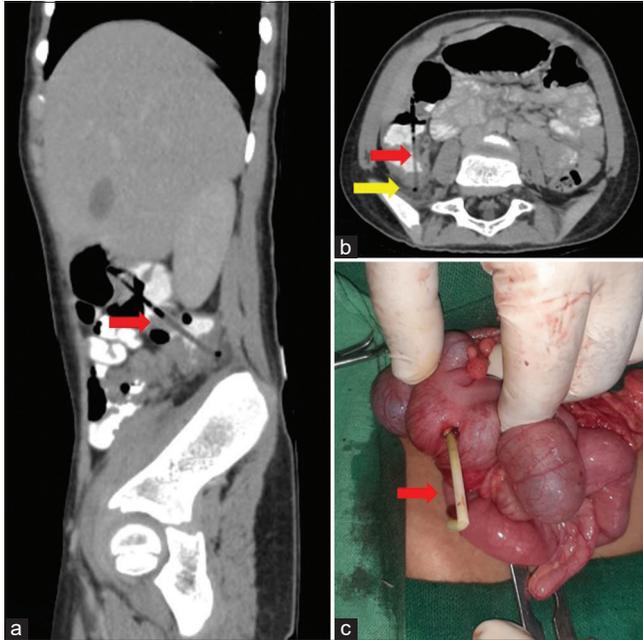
Sagittal and axial reformatted images of contrast-enhanced computed tomography abdomen shows presence of linear hollow hypodense structure in cecum and ascending colon with its inferior tip abutting the posterior wall of cecum (red arrow in a and b). A small collection was seen adjacent to it in retroperitoneum with few air foci yellow arrow in (b). Intraoperative image shows plastic stick (red arrow in c).
